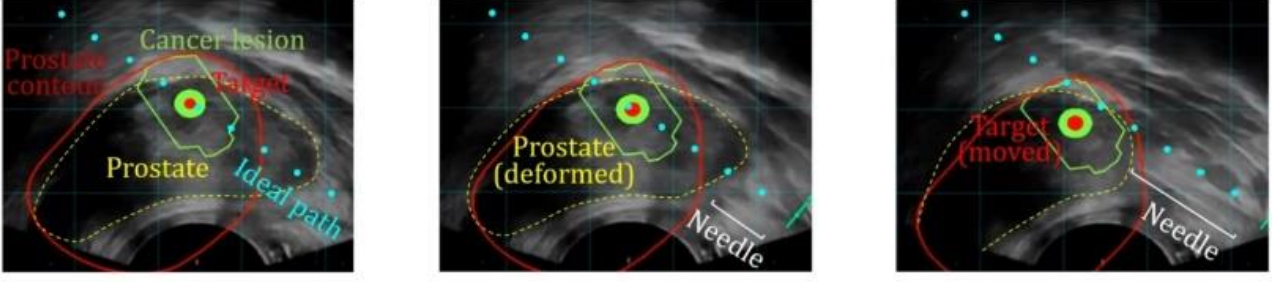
Ultrasound images of the insertion of a needle in the prostate. The needle (white) causes the prostate (yellow) to displace and deform, resulting in a deviation of the target (red) from the ideal insertion path (blue) [15].
